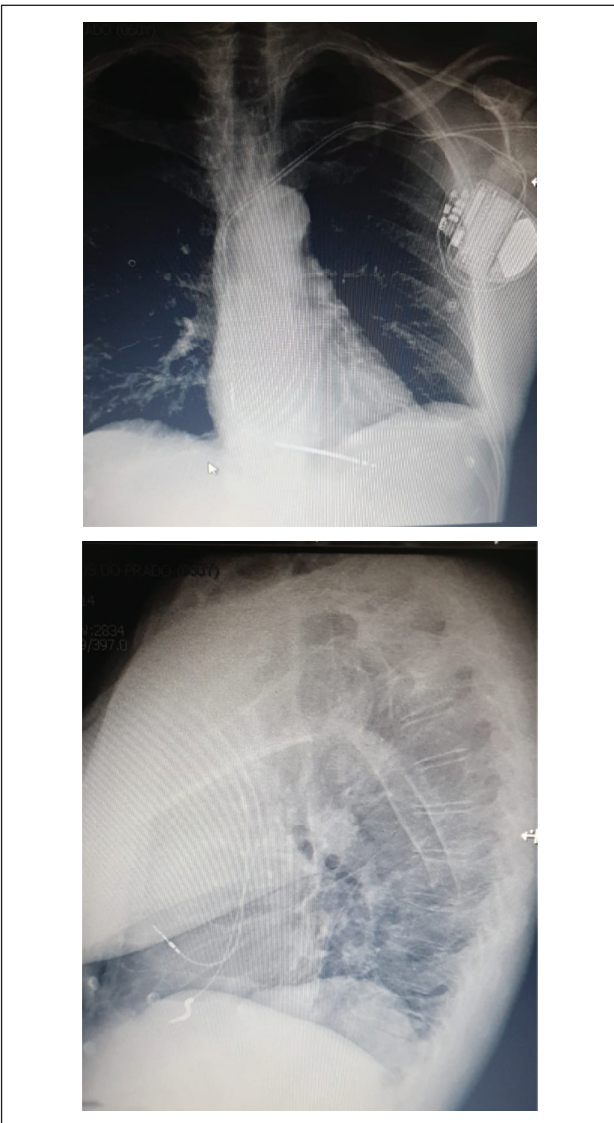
Chest X-ray PA/profile showing the correct positioning of the electrodes.
